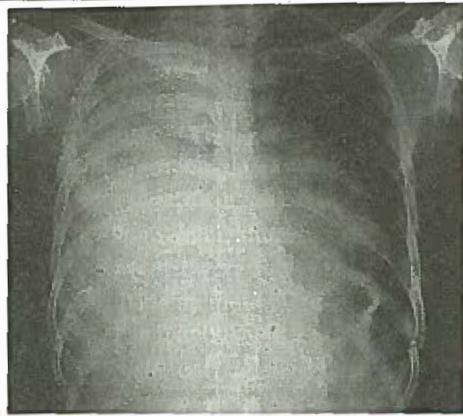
X-ray of pleural effusion: Mesothelioma, showing increased density of hemithorax with central mediastinum and consolidation due to pneumonia
